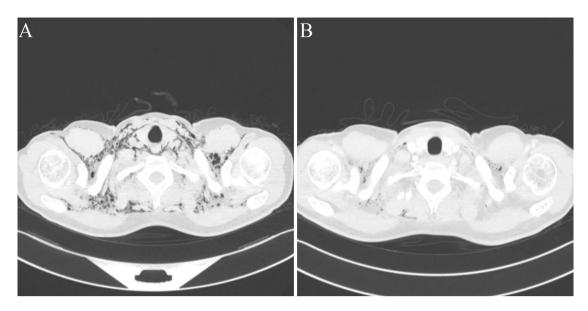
CT scan showing subcutaneous emphysema of neck — at diagnosis (A) and (B) before discharge
